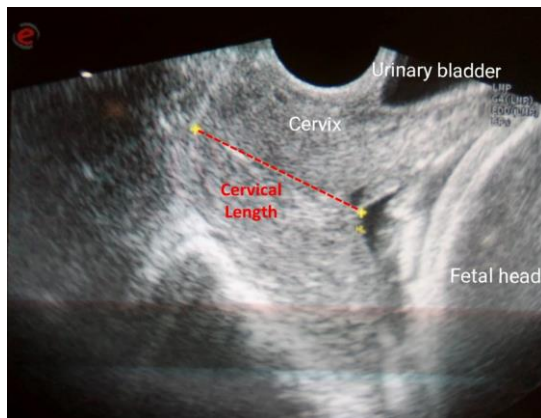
Transvaginal sonographic examination demonstrating measurement of cervical length from internal os to external os (Dashed red line).
